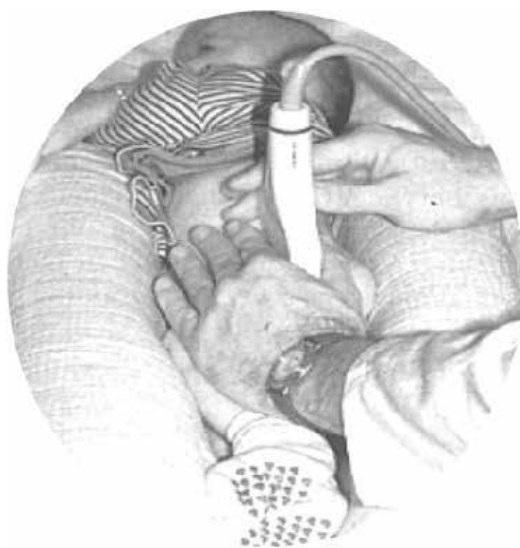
Child hip examination ultrasound.
